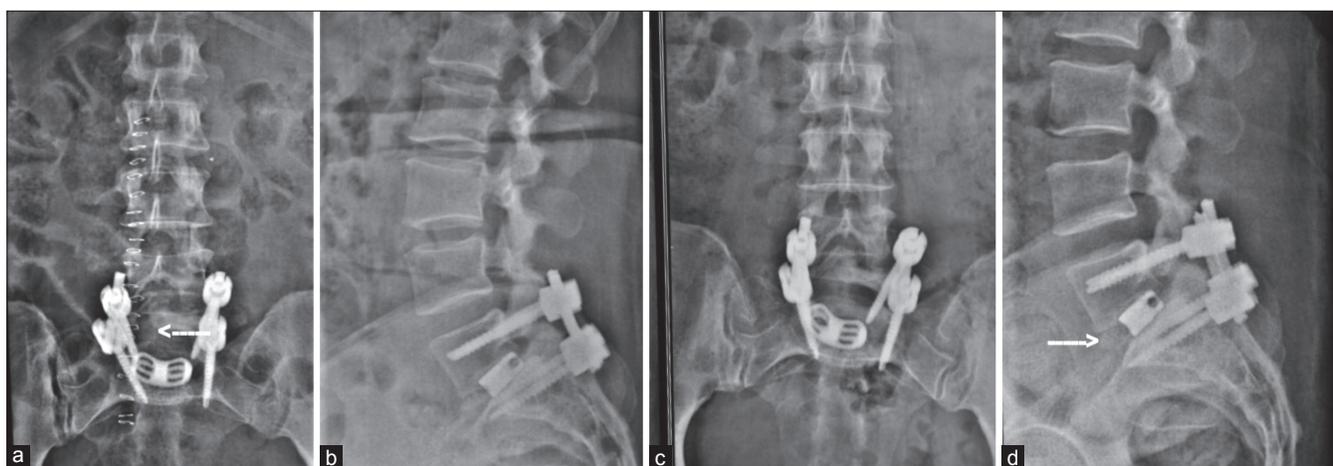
(a) Postoperative X-ray lumbosacral spine anteroposterior view and (b) lateral view showing good implant position and the transforaminal approach (arrow). (c) 1 year followup X-Ray anteroposterior view and (d) lateral view showing listhesis reduction and radiological fusion (arrow)
